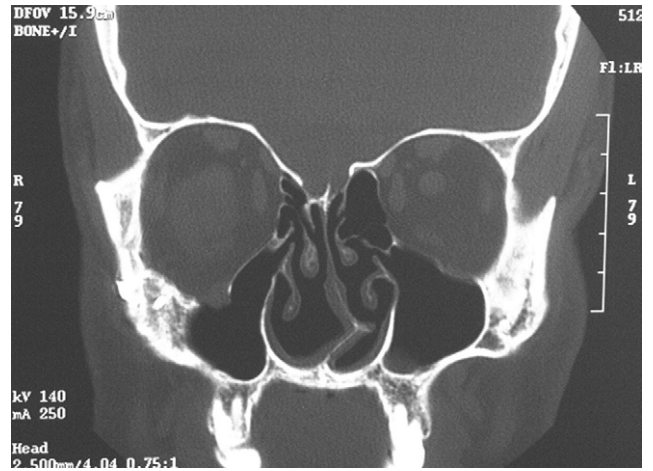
Preoperative CT scan in the coronal plane demonstrates rotated malpositioned right zygoma and entrapped inferior rectus muscle with increased orbital volume.
